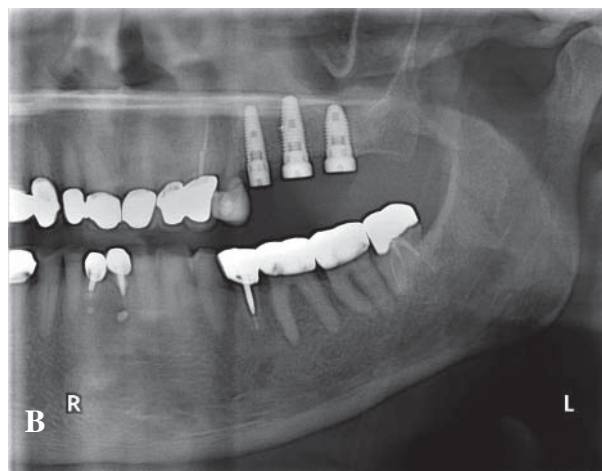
A. NobelGuide™ plan for 3 implants in the posterior left maxilla. Note the parallelism of the planned implants, B. Postoperative panoramic radiograph, C. Final restoration.
